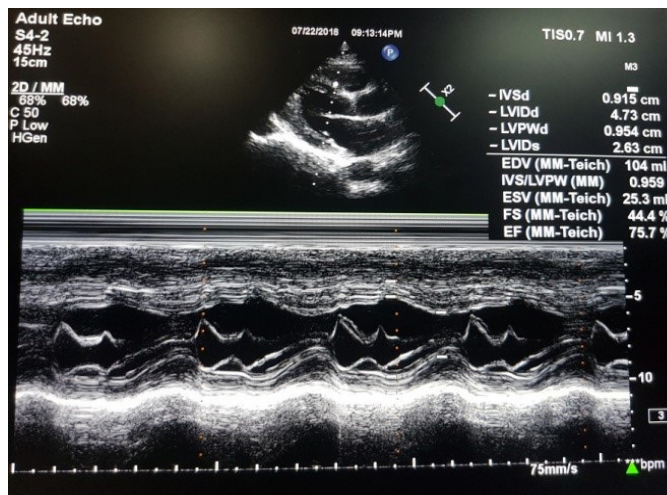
Echocardiography: showing normal interventricular septum at base and hypertrophy of apex.
